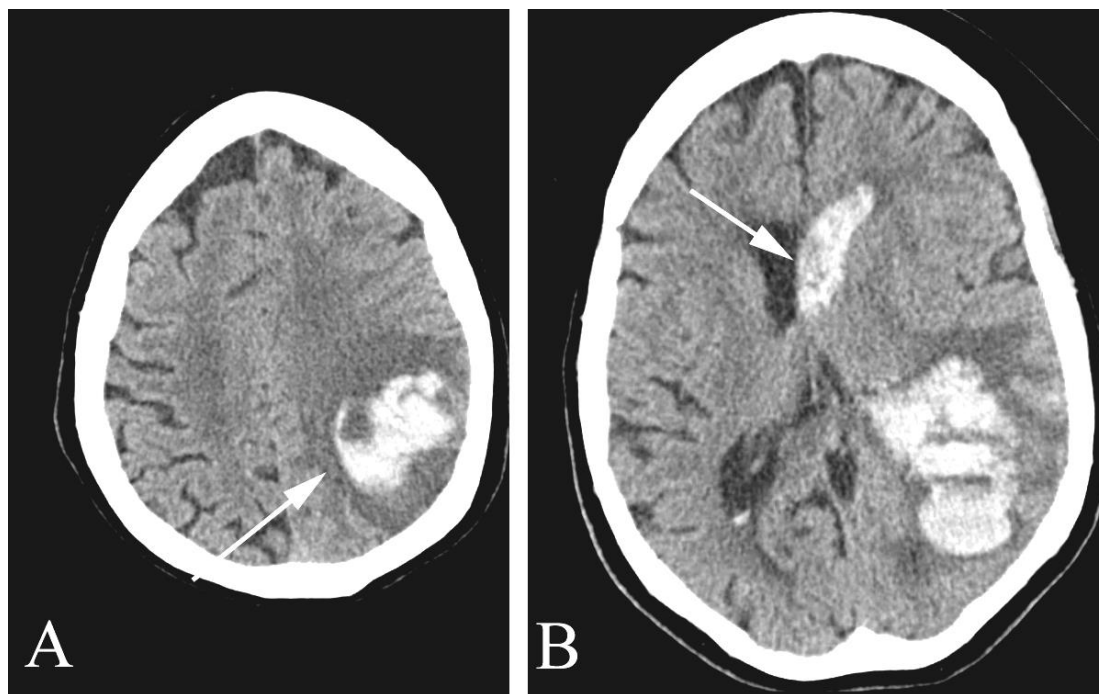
Intraparenchymal and intraventricular hematoma in an anticoagulated 79 year old with headache and acute mental status changes. A. Axial unenhanced CT shows extensive hemorrhage into the posterior left frontal lobe (arrow). B. Axial unenhanced CT demonstrates hemorrhage extending into the parietal lobe and into the lateral ventricle (arrow).
